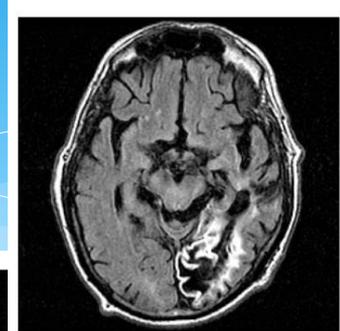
MRI scan (axial T1 sequence) showing large cortical infarcts in the dominant (left) hemisphere consistent with multi-infarct dementia.
